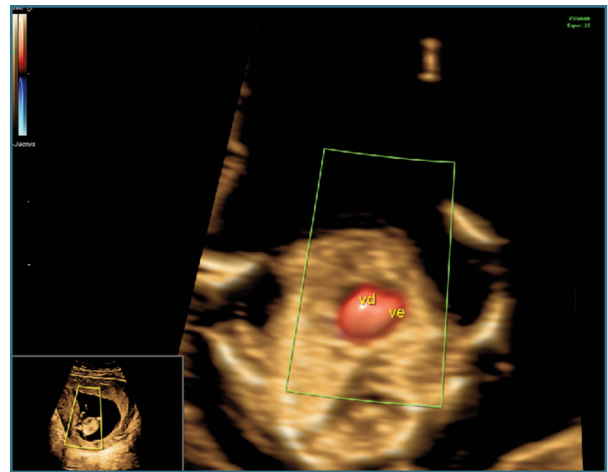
Ultrasonographic evaluation performed at 12 weeks and 4 days showing a suspected interventricular septal defect (vd: right ventricle, ve: left ventricle).
